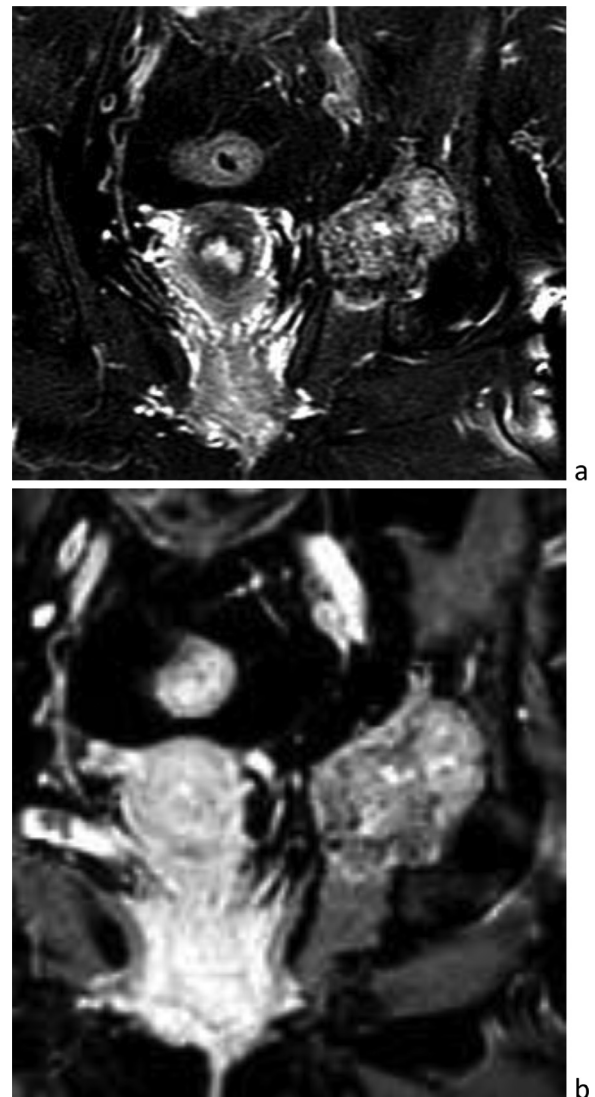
A and B: Coronal precontrast T2 fat saturated (A) and postcontrast T1 fat saturation MRI (B) in April 2022 demonstrating 5.3 × 5 cm left acetabular lesion, extending into the medial pelvic side wall, similar in location to the initial chondroblastoma.
